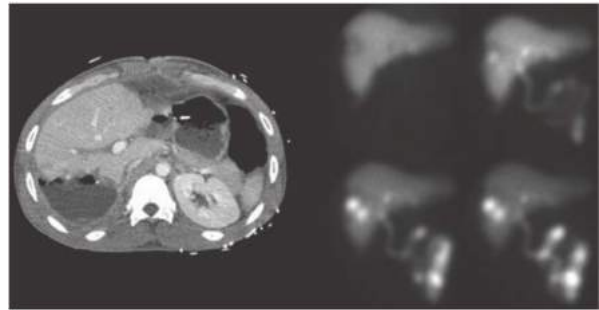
• Images from a HIDA scan (four images on right) of a trauma patient with a liver laceration. There is tracer accumulation in the region of the right hepatic lobe, which corresponds to an increasing fluid collection on CT.
